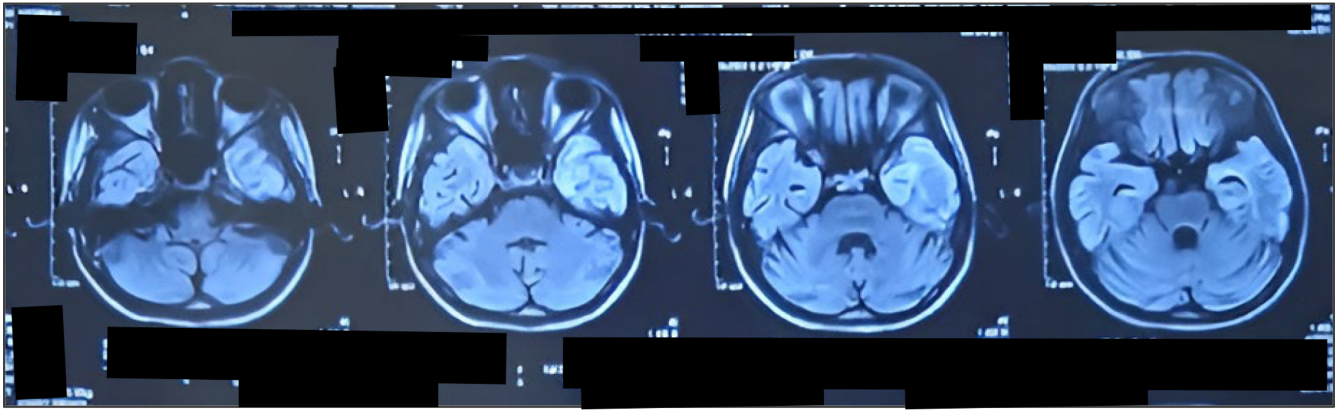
MRI of the brain showing bilateral temporal enhancement.
